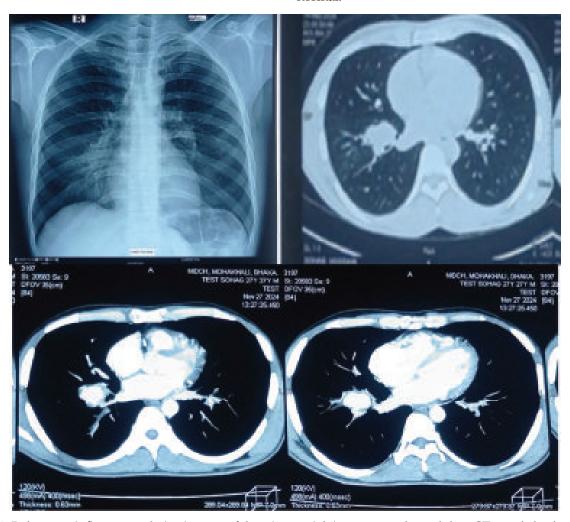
Pulmonary inflammatory lesion in x-ray of chest (upper right), contrast-enhanced chest CT revealed pulmonary consolidation in both lung, prominent on right and mediastinal zone (upper left) and CTPA revealed pulmonary pseudoaneurysm (lower two photos).
